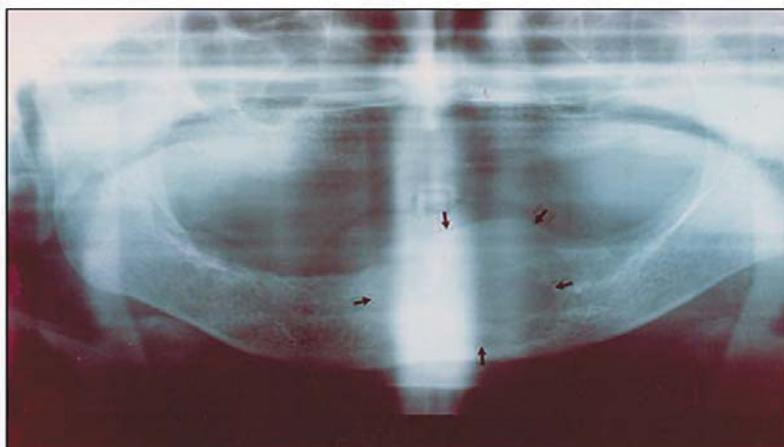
Panoramic radiography of CGCG in an edentulous area showing cortical expansion in the mandibular incisor-premolar area.
